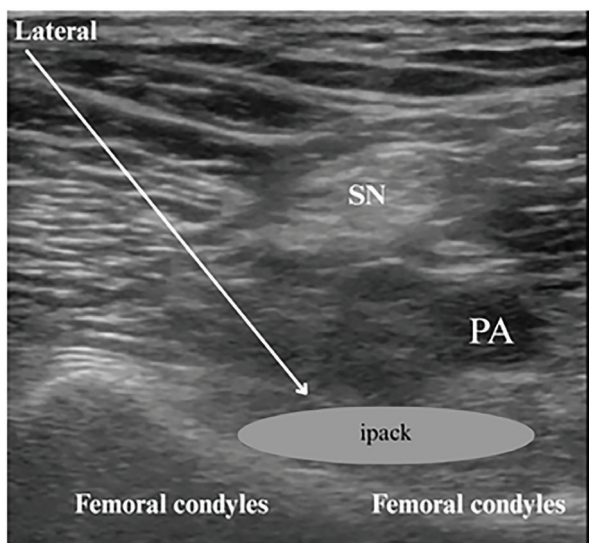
Ultrasound image of interspace between the popliteal artery and capsule of the posterior knee (IPACK) block
